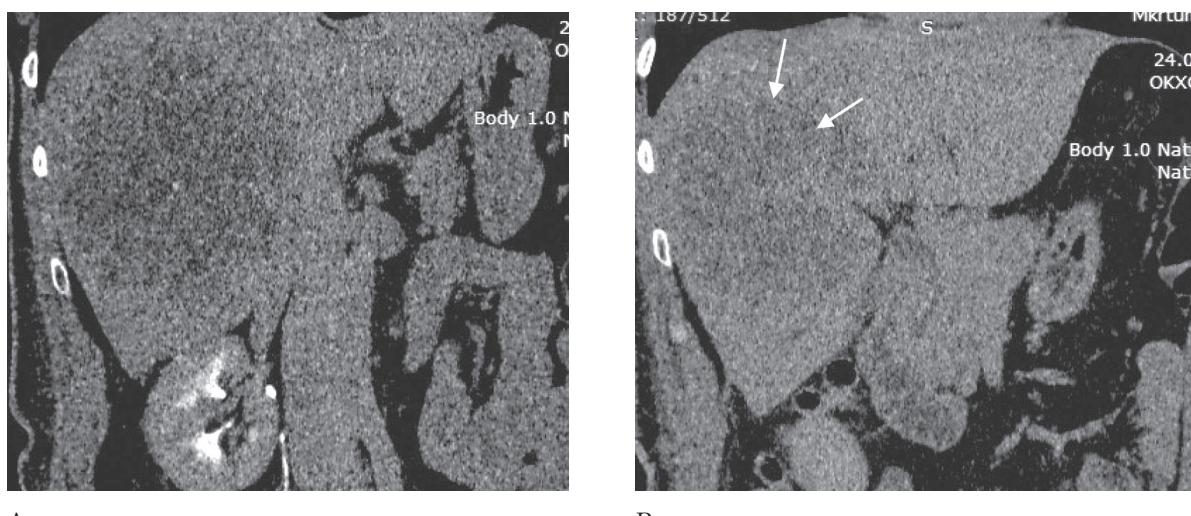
Abdominal CT with contrast enhancement (August 2015): A — tumor occupies almost the entire right lobe of the liver; B — transition to the fourth segment of the liver (arrows)
